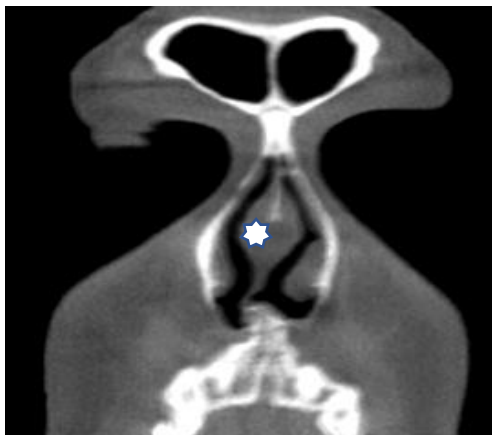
Coronal computed tomography (CT) with septal swell body
